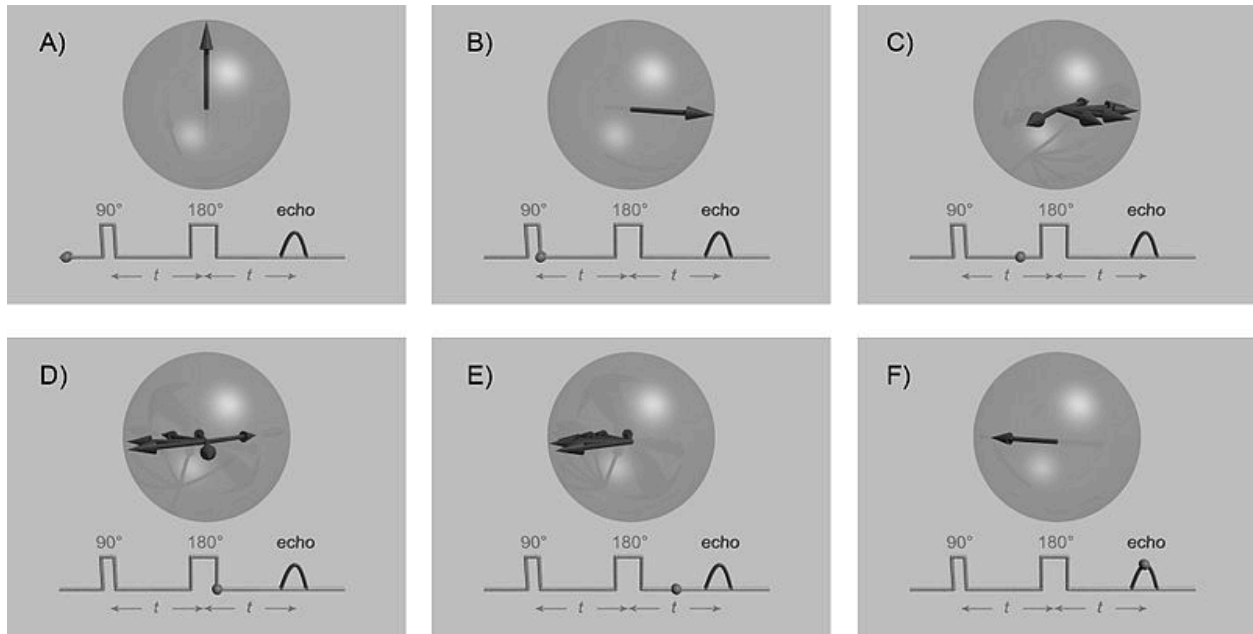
Part A depicts the magnetization dipole moment generated when all the hydrogen atoms are aligned to the strong magnetic field generated by the MRI machine. After a 90° radio-frequency pulse is triggered, this magnetic dipole will shift in the direction of the radiofrequency pulse (e.g. or perpendicular to the strong magnetic field, part B). At this moment, inhomogeneities occur and will slow down or speed up its precession rate of the dipole moment (known as dephasing", part c). Hence, another 180° radiofrequency pulse is introduced (part b). Slower precession atoms will speed up and faster precession atoms will slow down (part e) and eventually a stronger perpendicular dipole moment is acquired (part f). T2 relaxation signals occur during the dephasing of these atoms (part c-e) while T1 recovery images are acquired after the perpendicular precession (part f) returns to its stable condition aligned with the strong magnetic field (part a).
